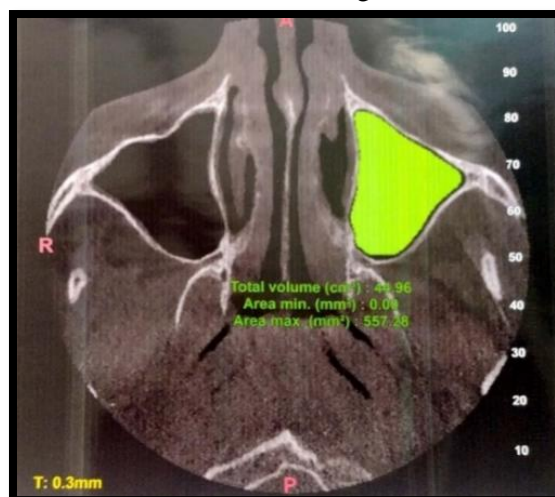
Axial Section Of CBCT
